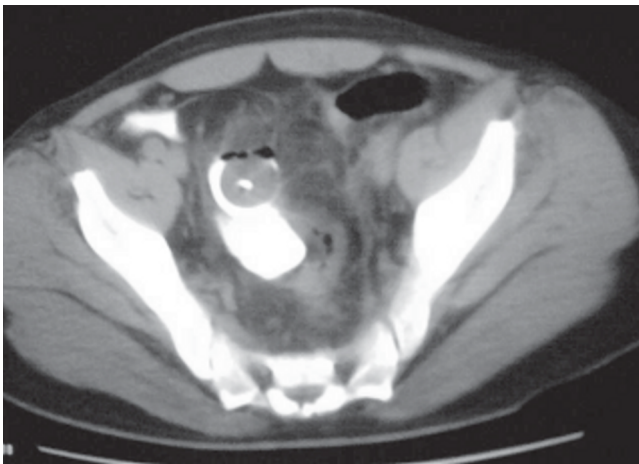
CT cystogram showing Foley's catheter bulb in peritoneal cavity and dye spill
